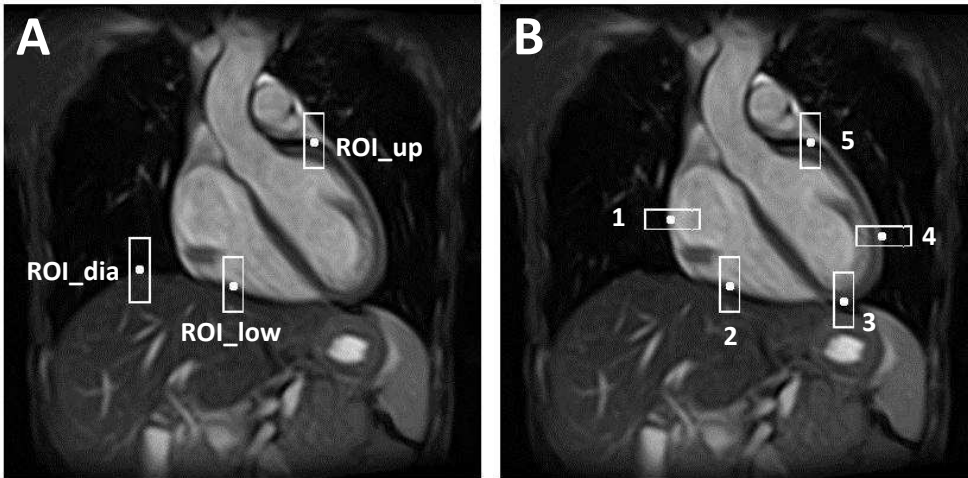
Coronal 2D SSFP MR images indicate the regions of interest (ROI) used for the nonrigid motion with SI translation and scaling (A), and affine motion model (B). The five ROIs in (B) were placed in the right (1), lower right (2), lower left (3), left (4), and upper (5) part of the heart.
